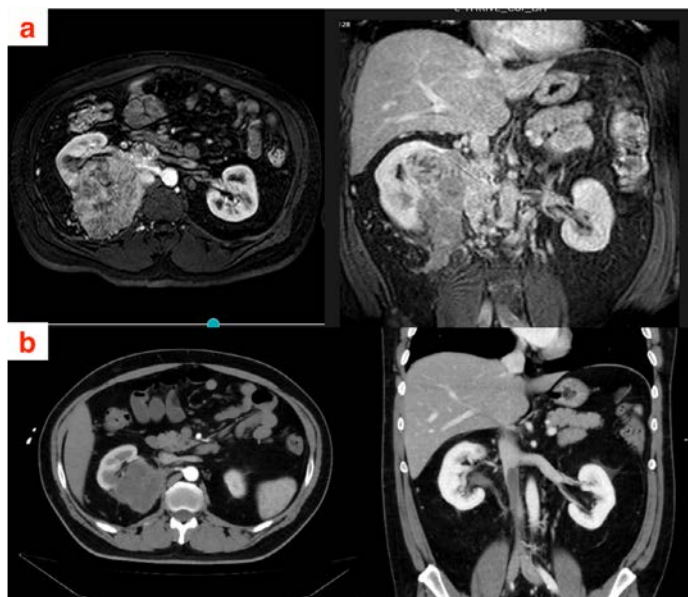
a: CT images of case 2 before systemic treatment; b: CT images of case 2 after systemic treatment
